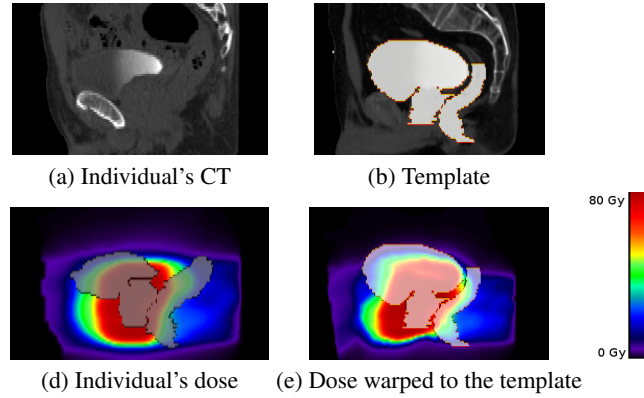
3D Dose mapping through an organ-driven non-rigid registration methodology. (a) A typical individual's CT; (b) Manually Segmented organs on the template; (c) Individual's TPS planned dose in the native CS; (d) Dose mapped to the template CS.
